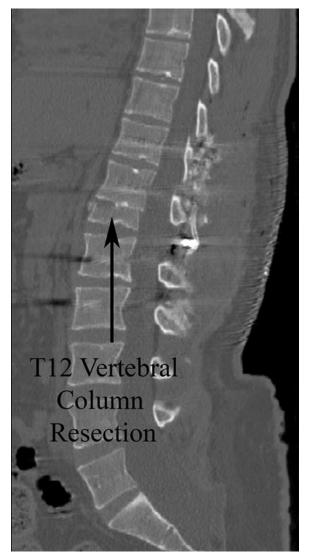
Postoperative sagittal CT reconstruction demonstrating a T-12 PVCSO and closure of the osteotomy in anatomical alignment along the thoracolumbar junction. Reproduced with permission from Hsieh PC, et al: J Neurosurg Spine 10:278–286, 2009.
